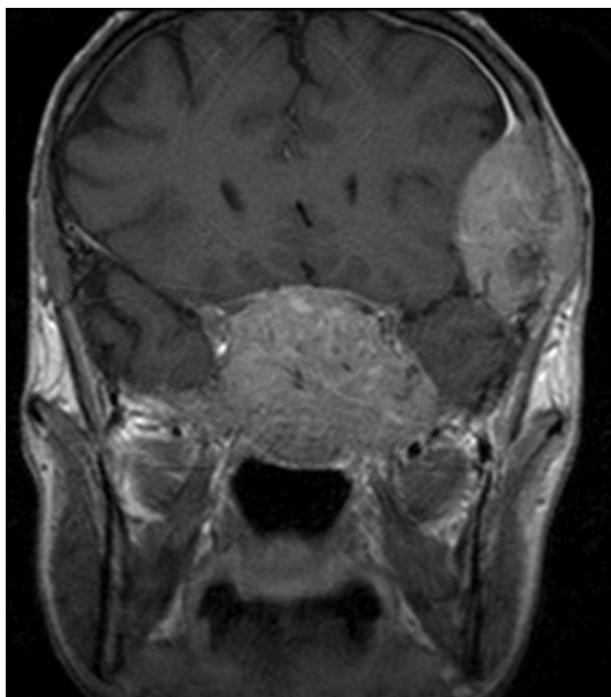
Coronal post contrast T1-weighted MRI scan showing large skull base mass compressing both prechiasmatic optic nerves. Note the left sided skull metastatic lesion as well.
